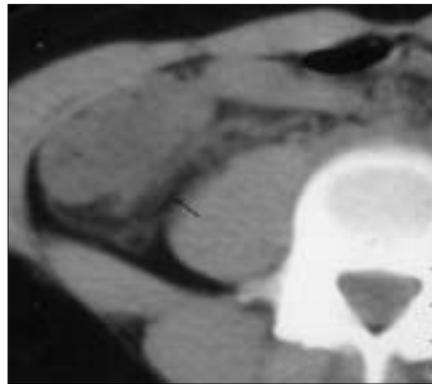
Axial CT image without oral or intravenous contrast medium administration in acute appendicitis. Note the dirty fat sign.
